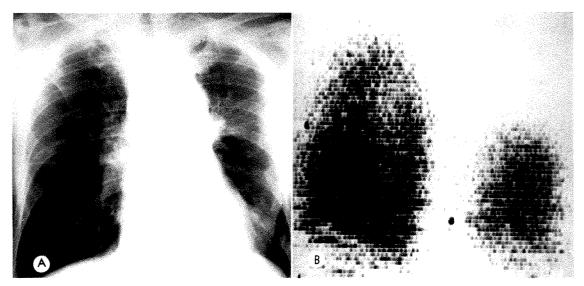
Net Improvement of Perfusion Following Radiotherapy. (A) Follow-up roentgenogram and (B) scan in patient OS 3 months after delivery of 3,000 r tumor dose in 14 days using supervoltage equipment. Comparison with initial examination (Fig. 2, A and B) shows marked reduction in tumor volume and return of perfusion to the lower half of the left lung. However, the appearance of ischemia in the upper half of the right lung suggests compromise of the right pulmonary artery by tumor extending across the mediastinum. The patient died shortly thereafter.
